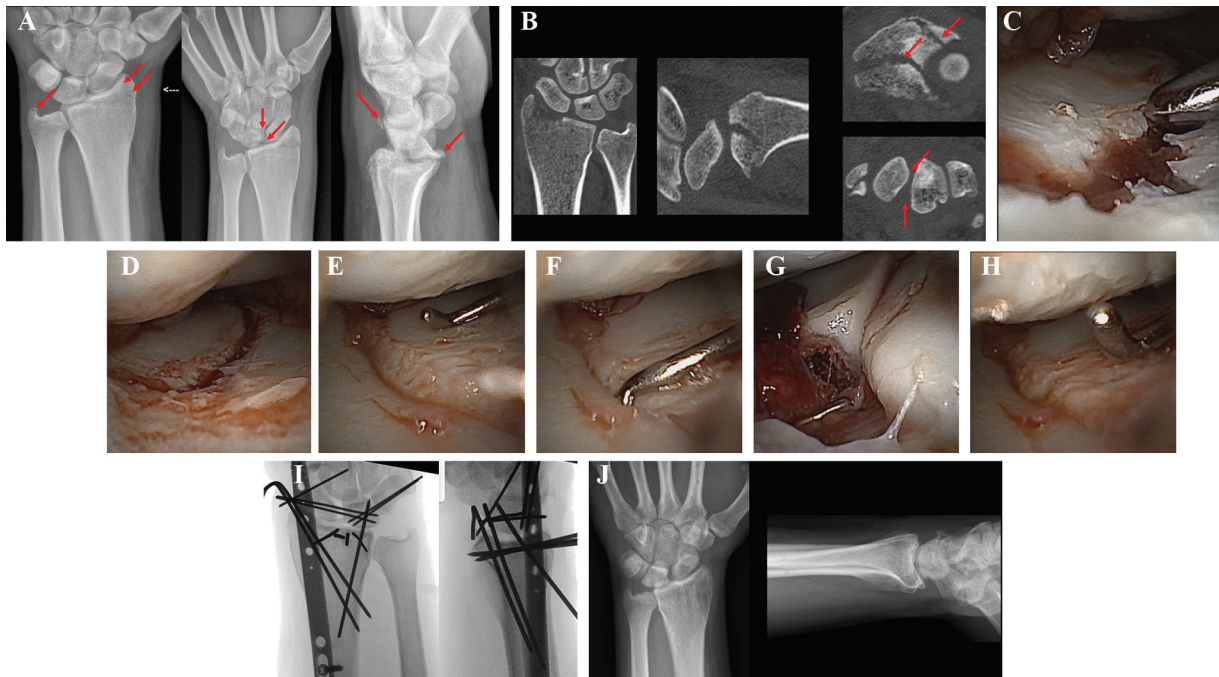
Details of the use of the NanoScope in the management of a perilunate-like injury to the wrist of a 22-year-old patient. (A, B) Radiographs and computed tomography (CT) scan demonstrating comminuted distal radius fracture with carpal ligament involvement. (C) Arthroscopic view showing displaced radial column injury followed by (D) reduction of articular step-off. (E) Midcarpal arthroscopy demonstrated scapholunate joint step-off, (F) which has been reduced and stabilized by carpal pinning. (G) Associated dorsal capsular avulsion off the lunate and triquetrum. (H) Associated chondral injury of carpus. (I) Fluoroscopic views demonstrating reduction of the distal radius and carpus and dorsal spanning plate application. (J) AP and lateral radiographs 4 months postsurgery.
